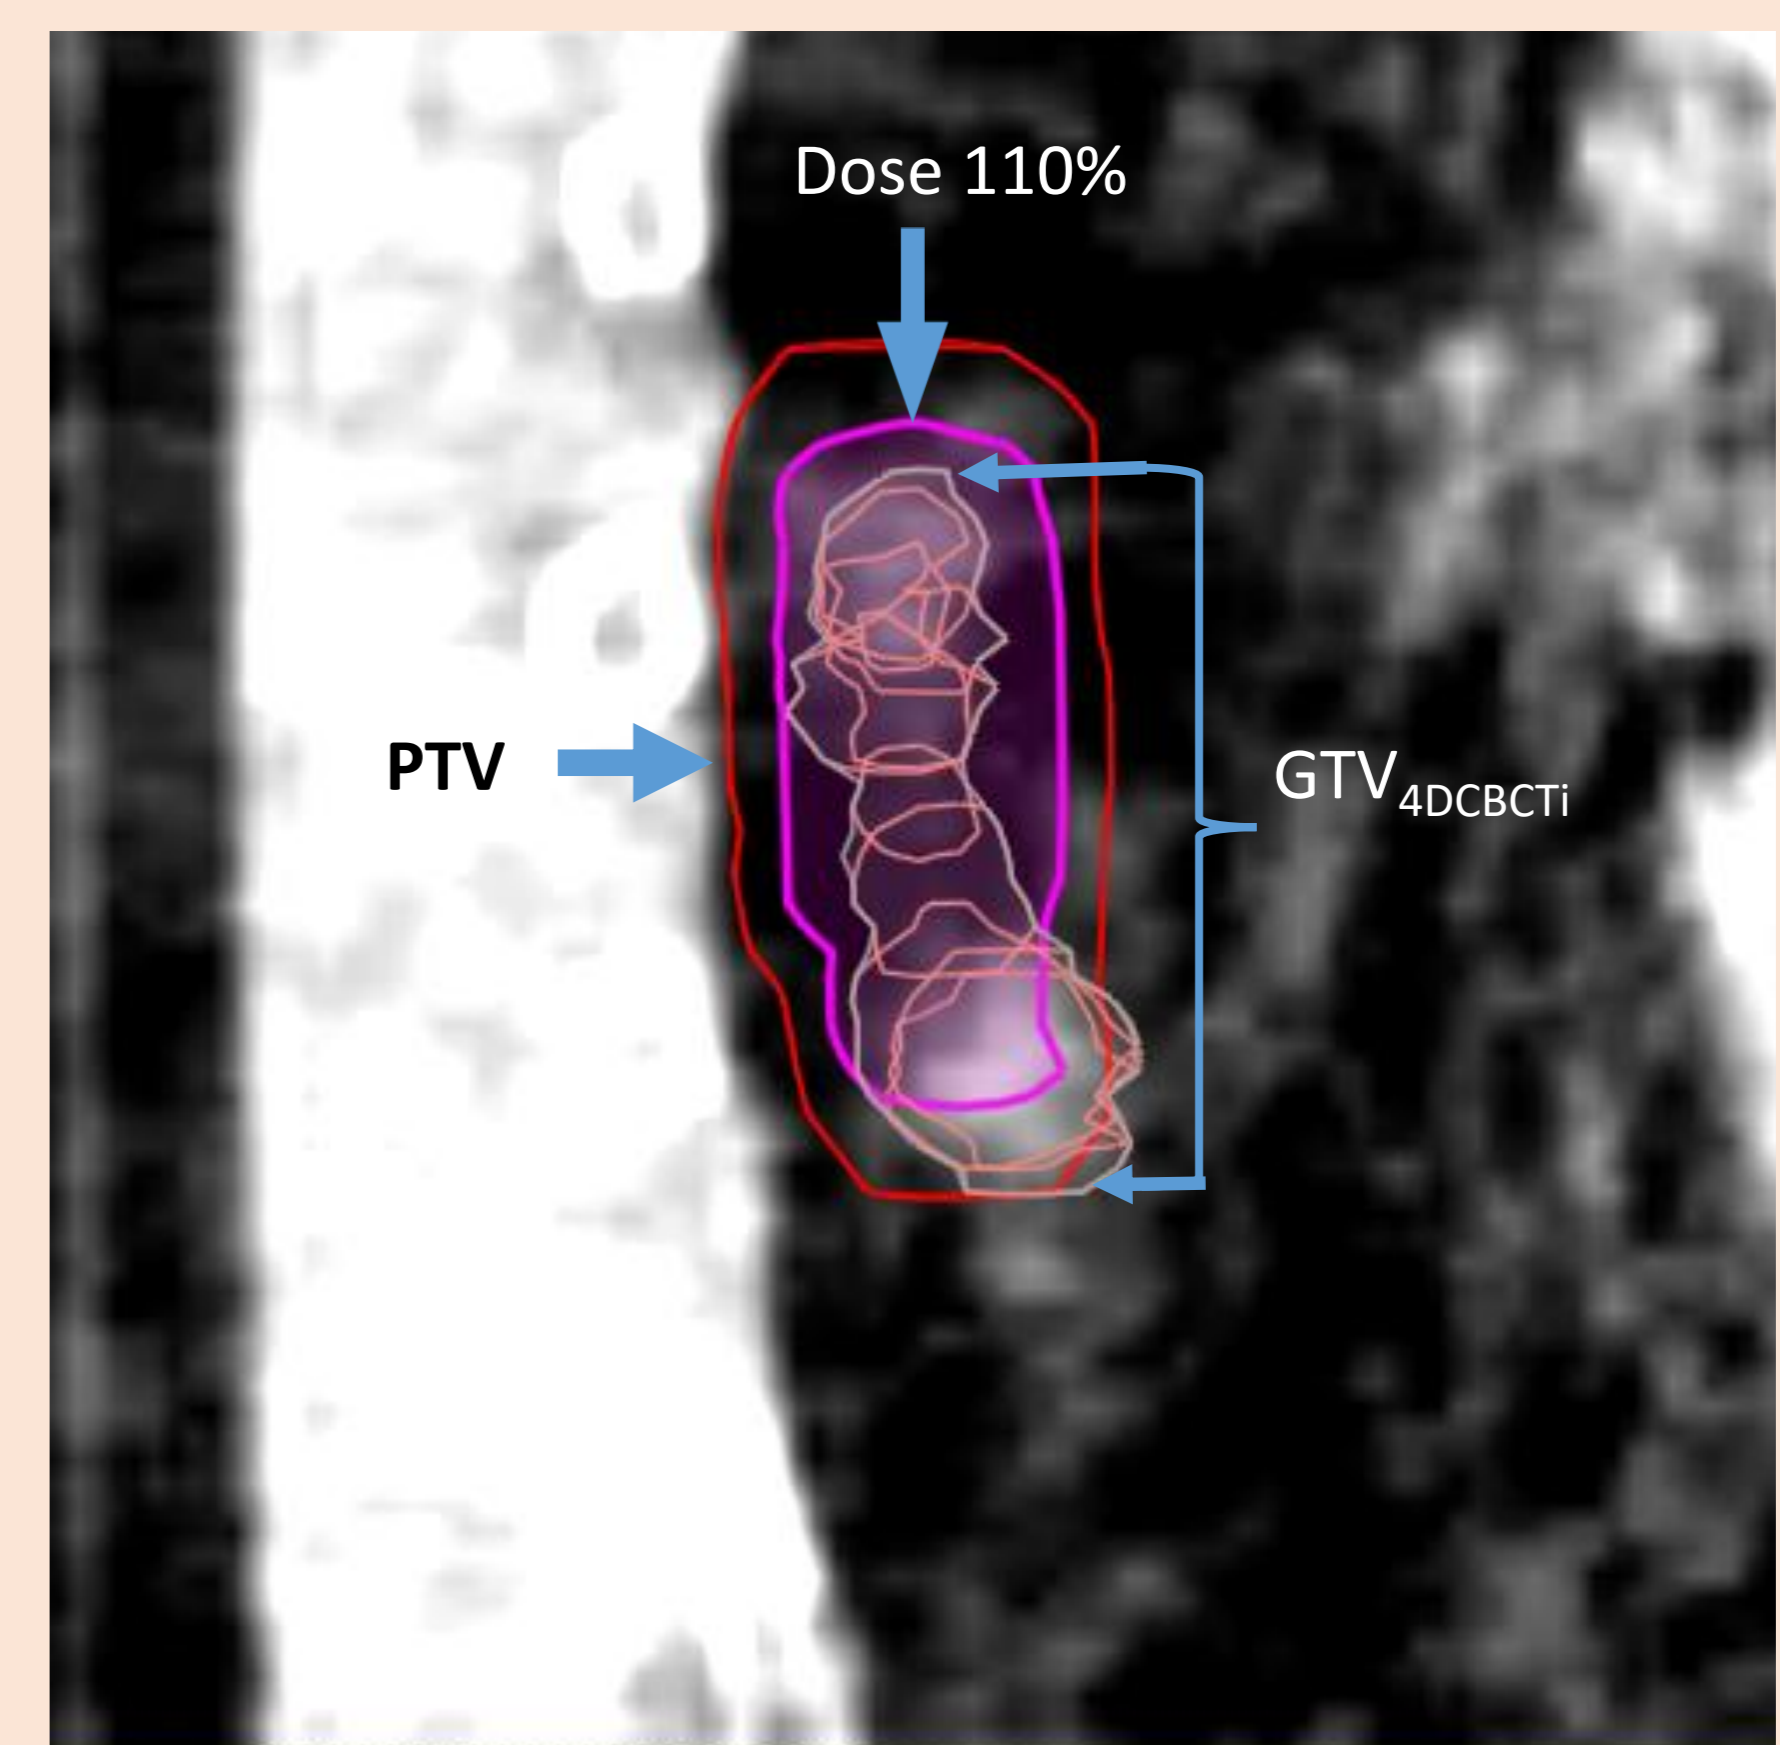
Patient 5 phase 0 4DCBCT, showing GTV_{4DCBCTi} from all 10 phases.
